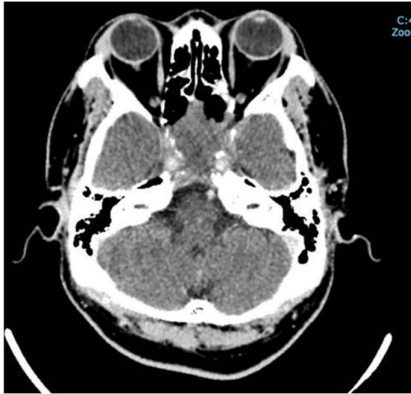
CT Scan results 4 months after first visit, the size of the mass tended to be reduced compared to the initial MRI.
